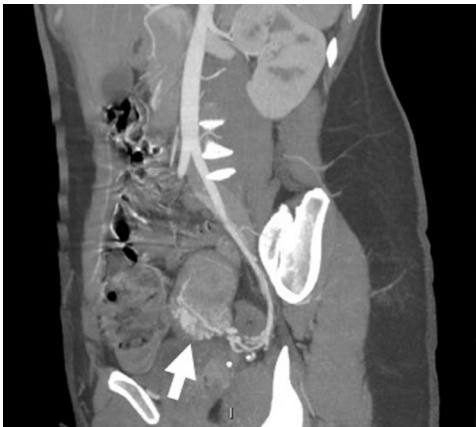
Same patient of Figs. 1 and 2. Contrast-enhanced CT scan in arterial phase with maximum intensity projection and oblique reconstruction. The acquired AVM is indicated by the white arrow into the uterine wall supplied by uterine arteries.
